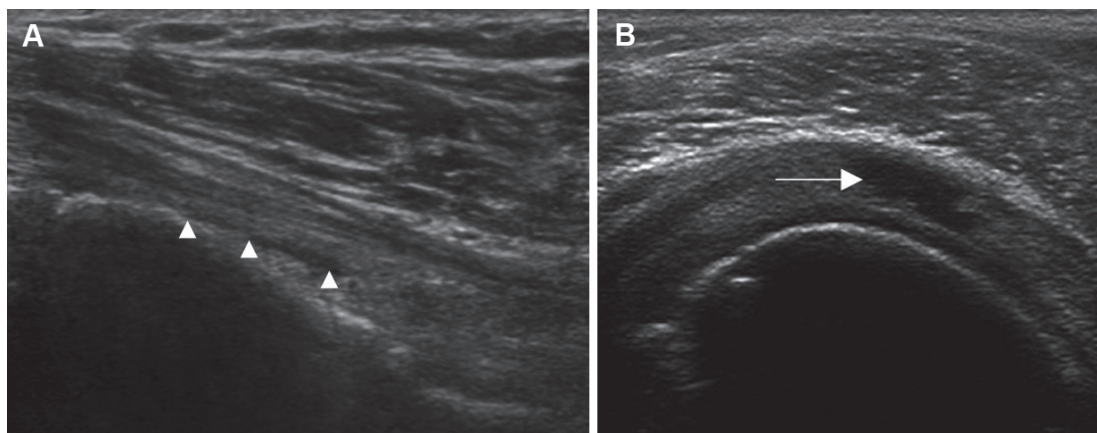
Ultrasound evaluation for shoulder soft-tissue injury. (A) Tendonitis: this longitudinal view of the bicipital tendon revealed hypoechoogenicity (arrowhead) around the tendon sheath and heteroechoogenicity of the tendon, which indicates inflammation with fluid infiltration. (B) Tear: this transverse view of the supraspinatus tendon revealed discontinuity of the tendon with a gap (arrow) along the tendon pathway, which indicates tendon tear.
